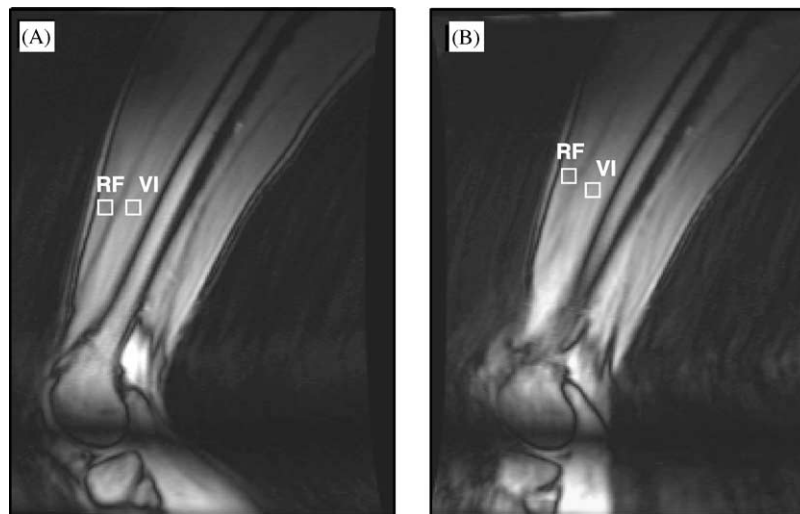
Sagittal plane cine-PC MR images of the thigh. Positions of 1 cm square tissue regions (white boxes) depict displacement of rectus femoris (RF) relative to vastus intermedius (VI) during active extension from approximately 65° of knee flexion (A) to near full extension (B) for one of the control subjects.
